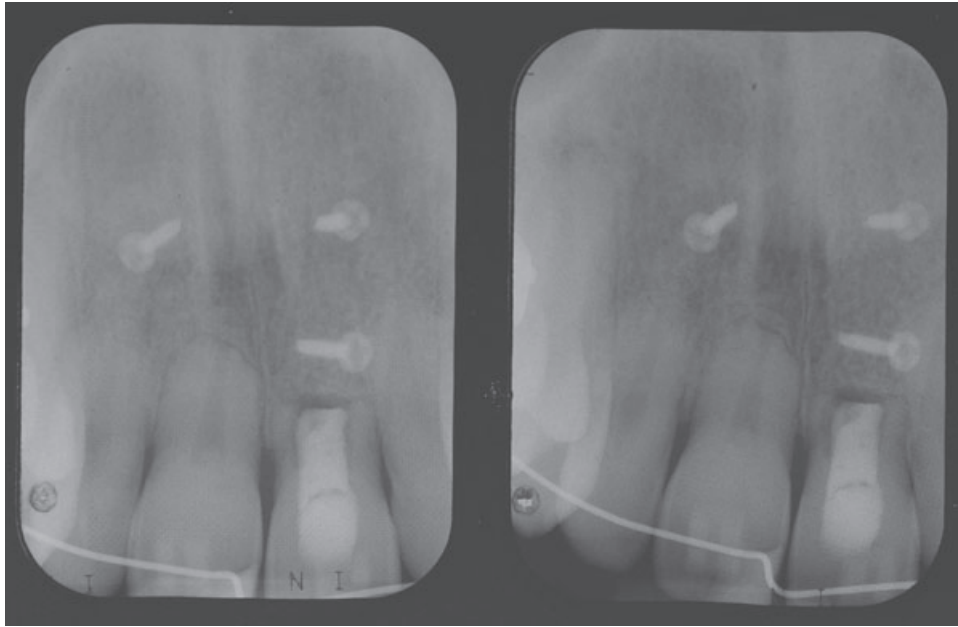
Radiographic view of the surgical site after autogenous bone grafting to enhance the buccolingual width of the bone.
